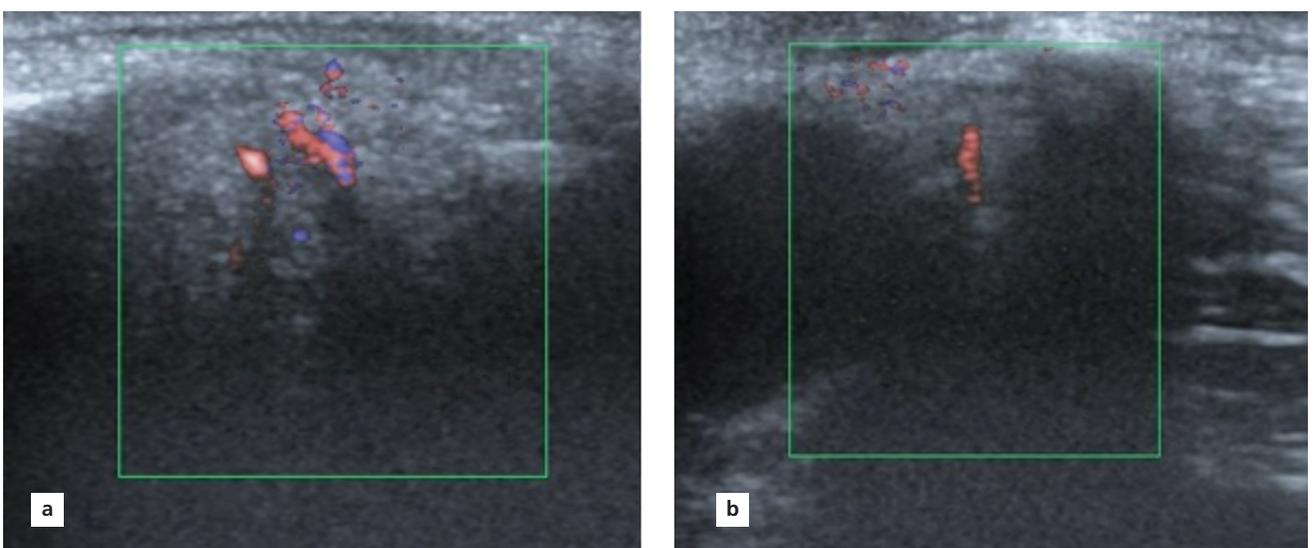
(a) Color Doppler sonography findings increased increased vascularity of the right lacrimal gland (right side), compared to (b) healthy participant.
